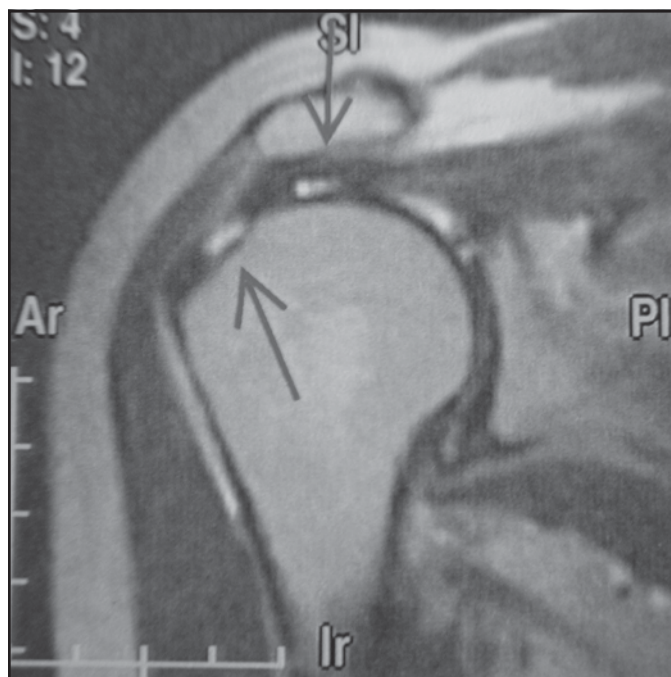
MRI confirming a complete tear of the supraspinatus, with retraction of the tendon. Distal and proximal fragments indicated by arrows.
